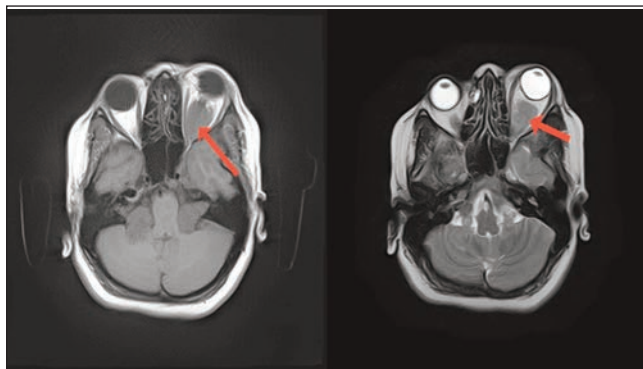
Left intraconal lesion showing significant enhancement, T1W MRI and T2W MRI, red arrows.
